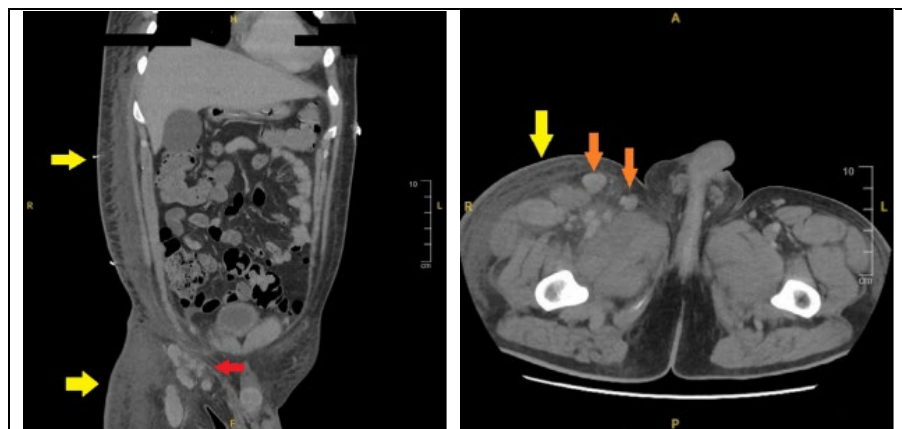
Coronal section of CT abdomen and pelvis showing subcutaneous edema throughout the abdomen and extending into the right upper thigh deep fascia & Transverse section of CT abdomen and pelvis showing subcutaneous edema of the right upper thigh deep fascia
